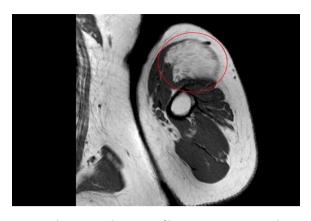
The tumor has an infiltrative pattern. Axial T1weighted MRI shows an intramuscular lipoma of the left shoulder. Its infiltrative pattern tends to invade adjacent musculature (inside the red ellipse)
